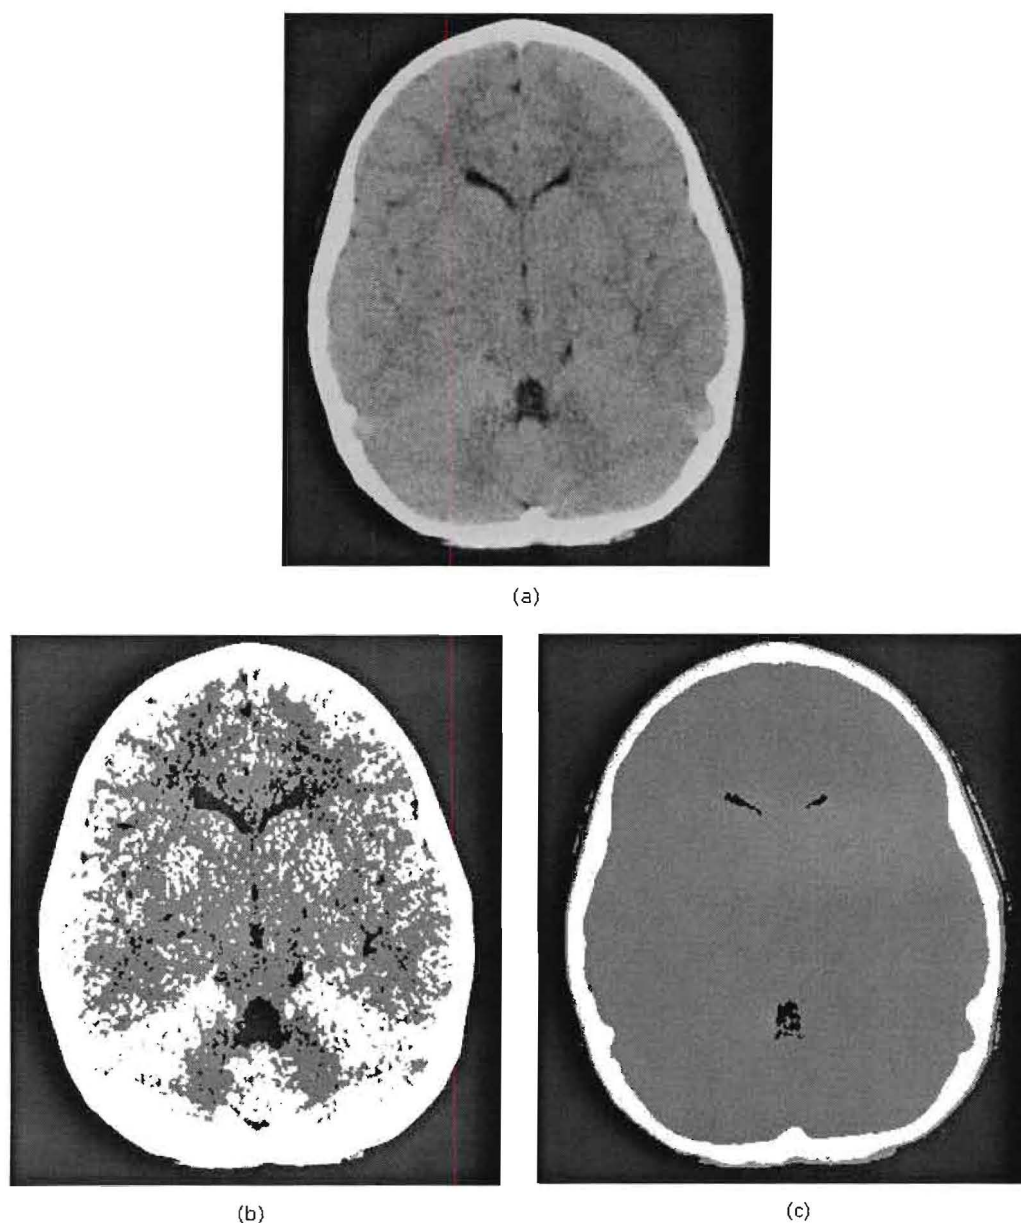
Images showing the comparative results of applying an FCM algorithm and a FMLE algorithm (a) shows the original brain CT image of a patient with a normal brain scan. In image (b) the scan has been segmented using fuzzy c-means clustering into 3 clusters, and image (c) has been segmented using the Fuzzy maximum likelihood estimation (FMLE) into 3 clusters.
